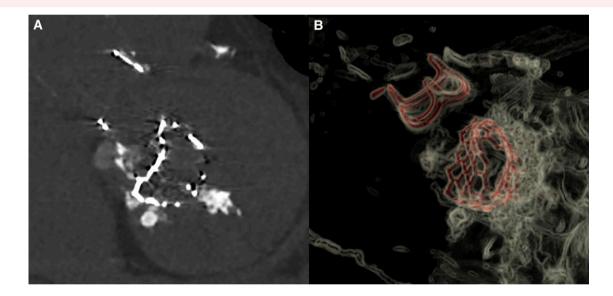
Computed tomography scan of mitral prosthesis after dilatation of left ventricular outflow tract. (A) Two-dimensional mitral prosthesis with D-shape deformation. (B) Three-dimensional mitral prosthesis with D-shape deformation.
